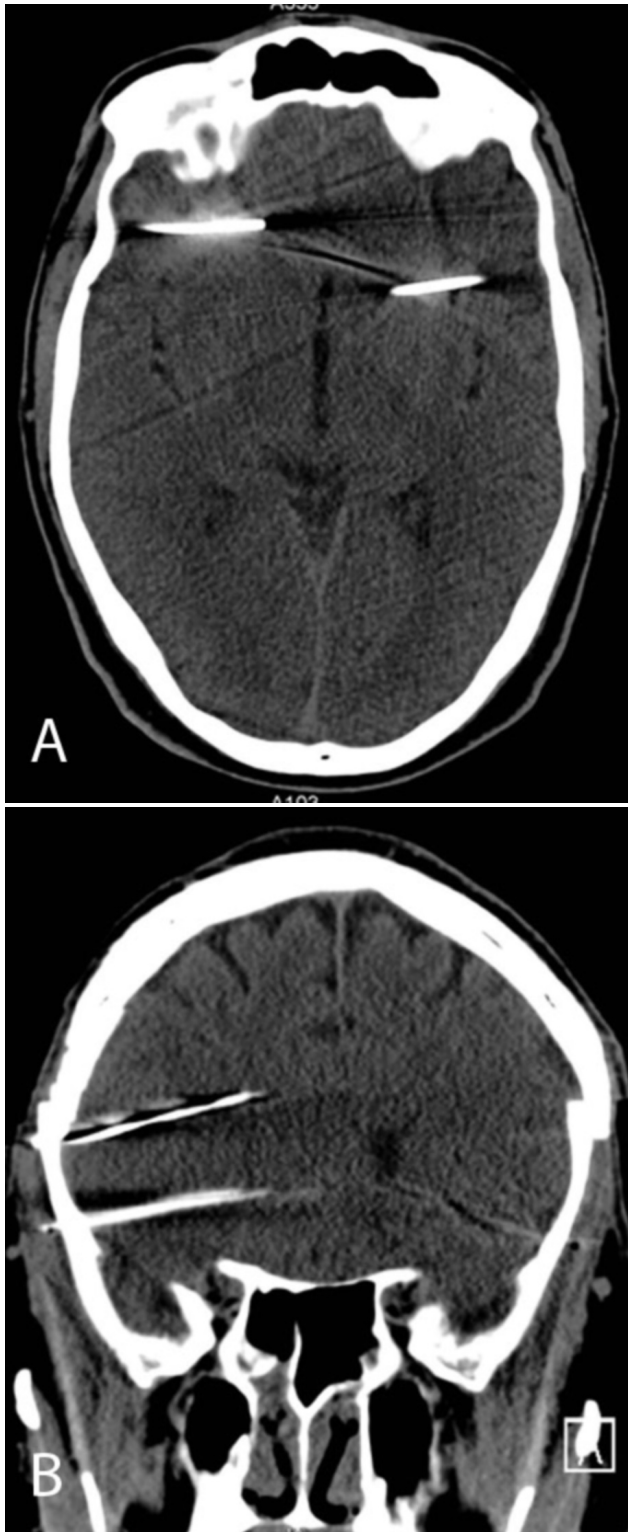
Nonenhanced head CT with axial image (A) and coronally reformatted image (B), showing three intracranial nails within both temporal lobes associated with a very small subarachnoid bleed. No evidence of parenchymal hematoma or mass effect is noted.
